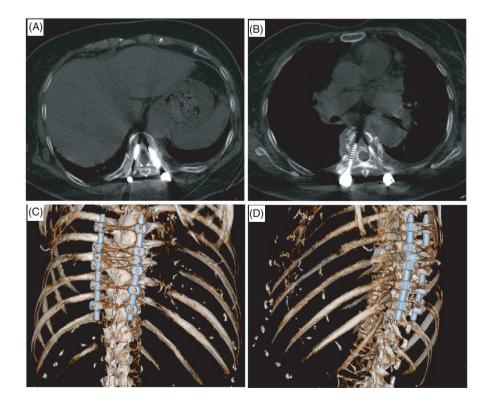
Patient re-examined by CT after the first surgery 18 months postoperatively. (A) This is a picture of bilateral pedicle screw placement in T10. (B) This is a picture of bilateral pedicle screw placement in T6. (C) This is a CT 3D reconstruction of the coronal plane. (D) This is a CT 3D reconstruction of the sagittal plane
